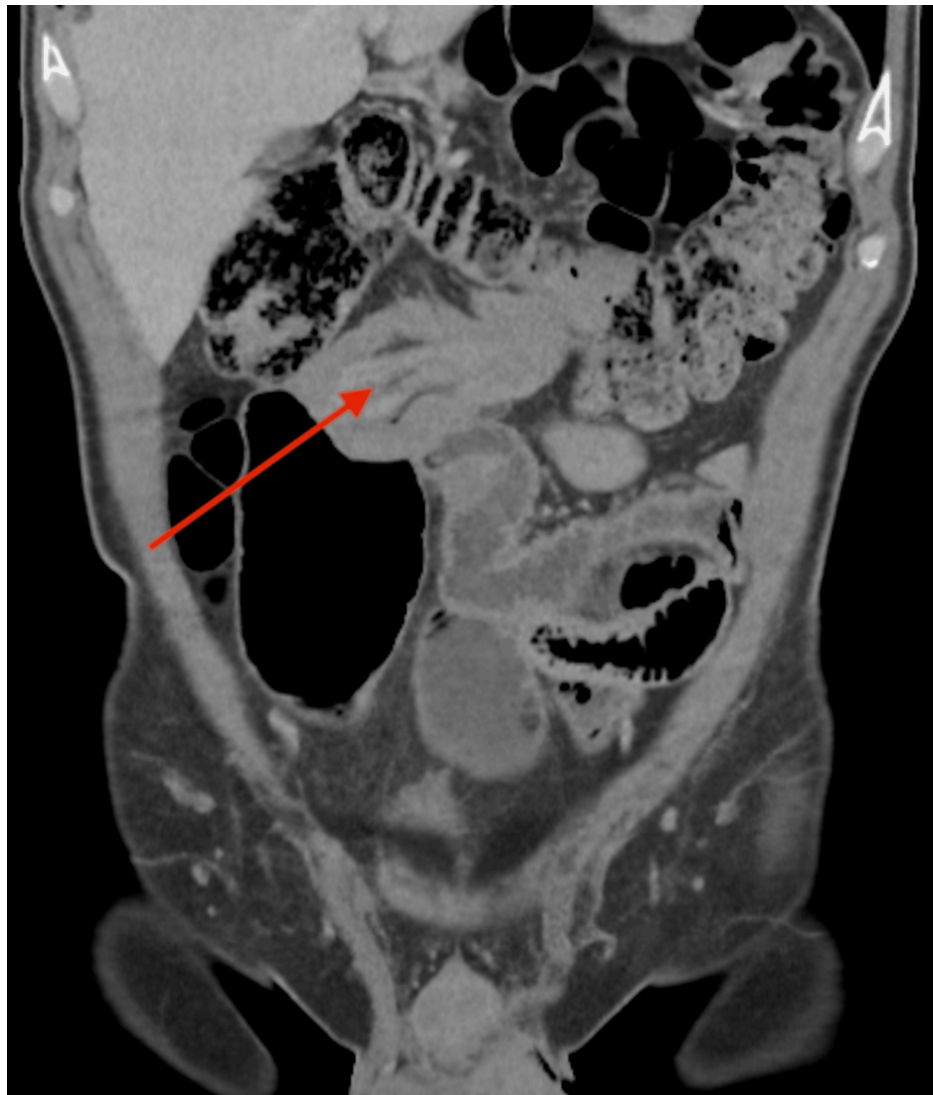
Coronal section of CT of the abdomen and pelvis showing the 'bowel-within-bowel' configuration (red arrow).
